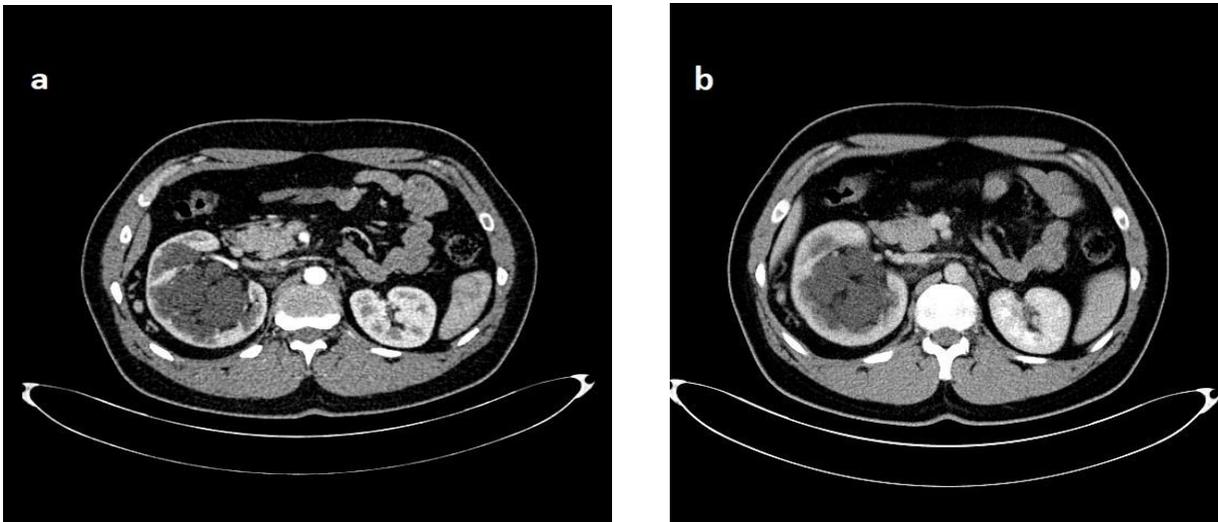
Axial (a) and coronal plane (b) of contrast enhanced CT of the abdomen in the arterial-venous phase demonstrates enlarged voluminosely right kidney, with fluid attenuation collections, hypodense lesions that are multiple lobulated, peripyelonic and intrarenal. On the right perirenal side venous collaterals of blood vessels are seen and ectopic and remarkable lymphatic nodes
